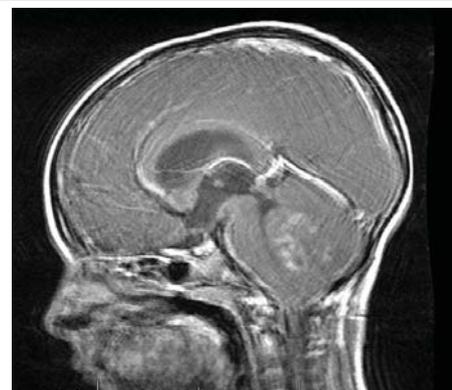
Sagittal T1 weighted post contrast MRI demonstrates an enhancing mass in the posterior fossa, likely arising from the vermis and extending into the fourth ventricle.
